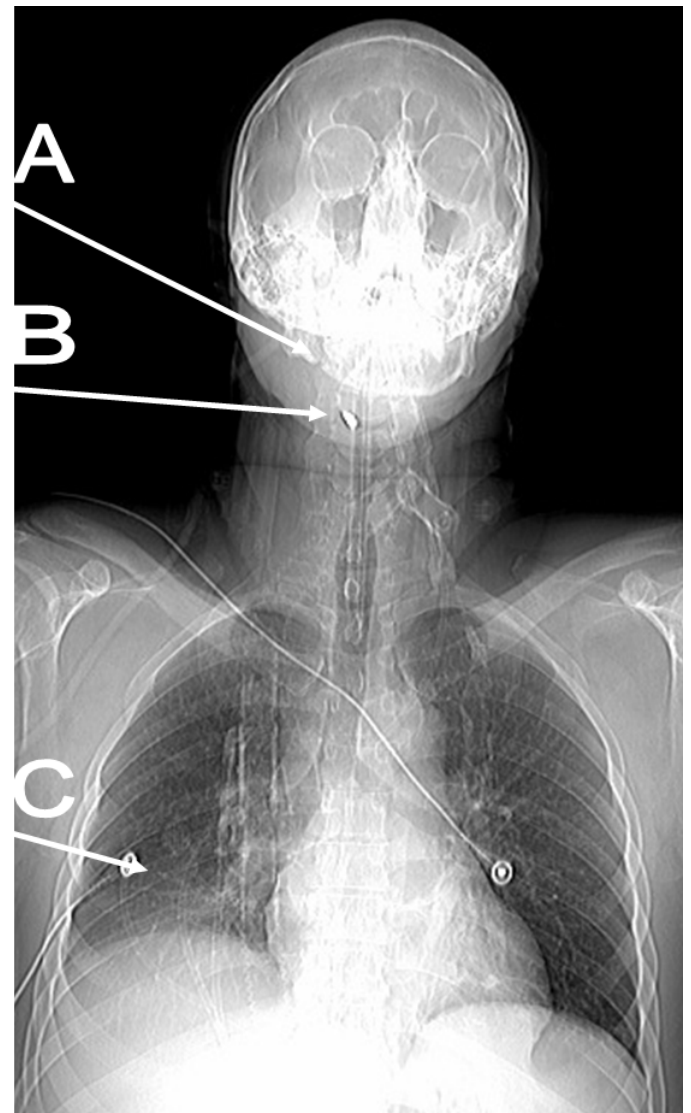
Radiograph of GSW patient. Note fracture of mandible (A), bullet (B) and developing RLL atelectasis (C).
